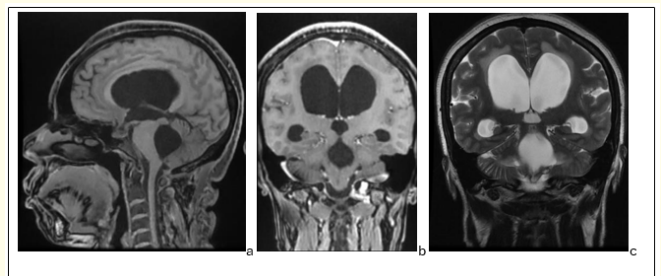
Pre-operative cranial MRI sections; a. Sagittal T1WI, b. Coronal T1WI + contrast, c. Coronal T2WI.
